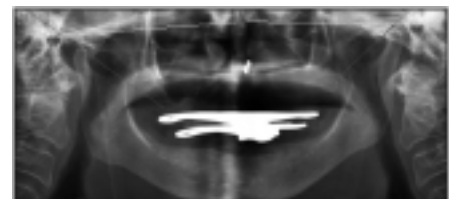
3 : OPG(Orthopantomograph) tracing showing angle of the sagittal condylar guidance.
